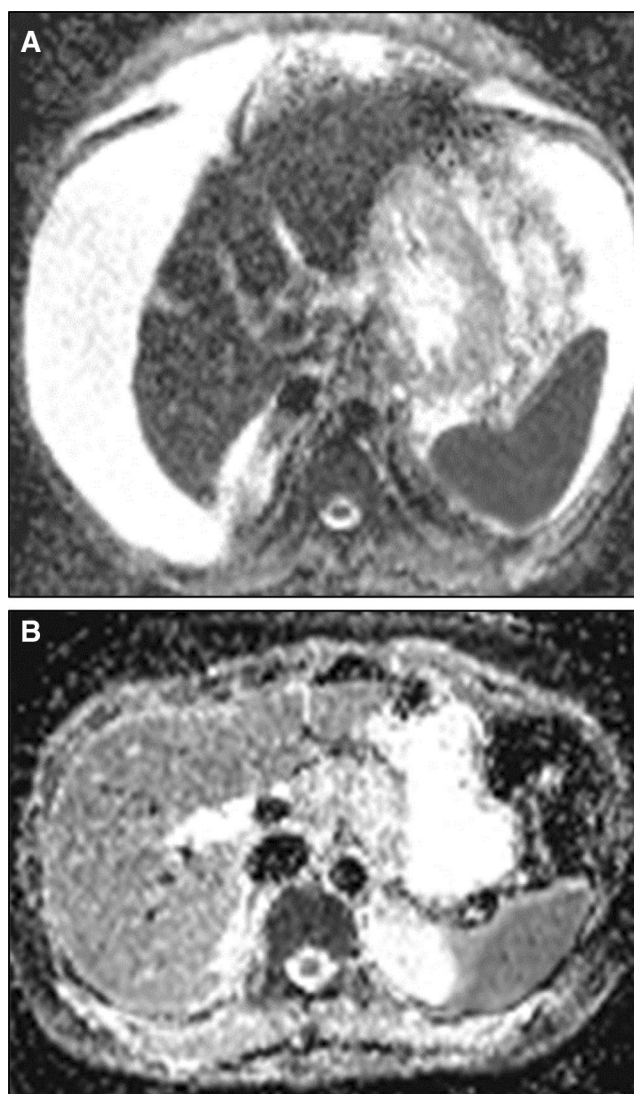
A, B ADC maps from MRI with DWI show lower ADC in a cirrhotic patient (A) compared with a patient without chronic liver disease (B).
